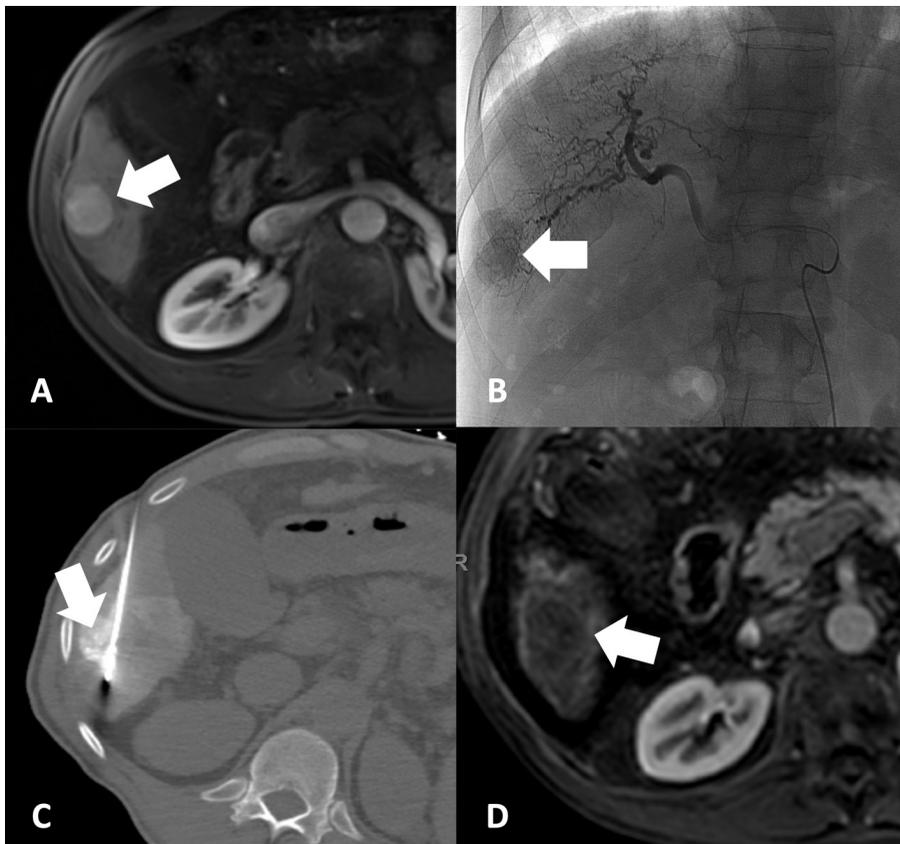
A 62-year-old man with cirrhosis secondary to hepatitis C. (A) Axial slice from a T1-weighted, contrast-enhanced magnetic resonance imaging (MRI) scan in arterial phase demonstrates a 3.2 cm hepatocellular carcinoma (white arrow) in segment 6. (B) Digital subtraction angiogram from the right hepatic artery during conventional transarterial chemoembolization (cTACE) demonstrates tumor hypervascularity (white arrow). (C) Axial slice from computed tomography obtained during percutaneous microwave ablation the day after cTACE shows retention of the radiopaque ethiodol in the tumor (white arrow) with the ablation probe adjacent to the tumor. Microwave ablation was performed with a 19 cm probe (AngioDynamics) at 140 watts for 6 minutes. (D) Axial slice from a T1-weighted, contrast-enhanced MRI scan in arterial phase 1 month after combined cTACE with percutaneous ablation demonstrates no residual enhancement (white arrow), consistent with a complete response. The patient is currently awaiting transplant.
